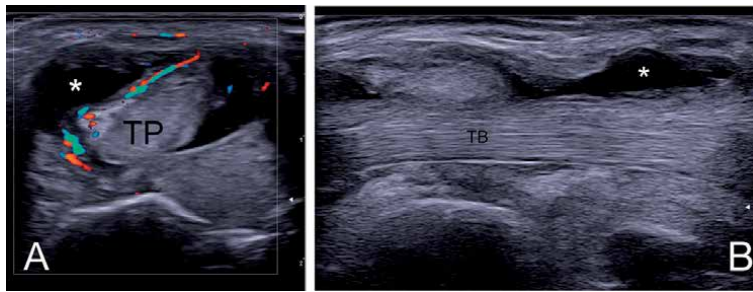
US images showing - tenosynovitis of the tibialis posterior (asterisk – tenosynovitis) in transverse, with Doppler activity (A) and longitudinal scan (B).
